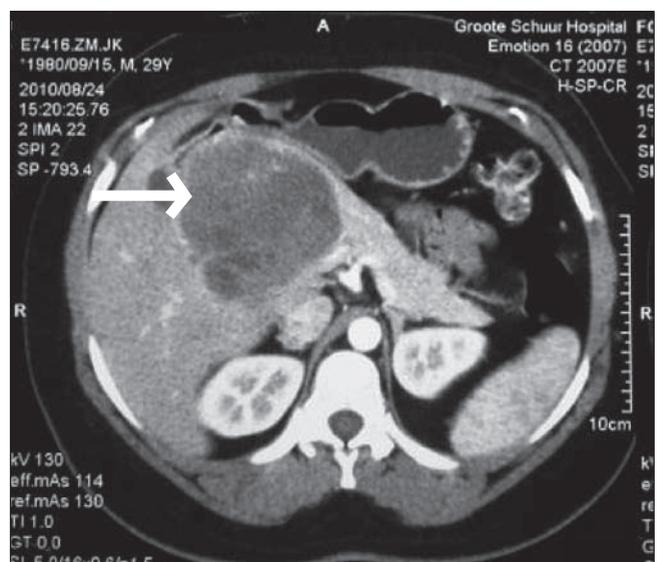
Computed tomogram showing the heterogeneous densities in a SPEN (arrow) involving the head of the pancreas.
